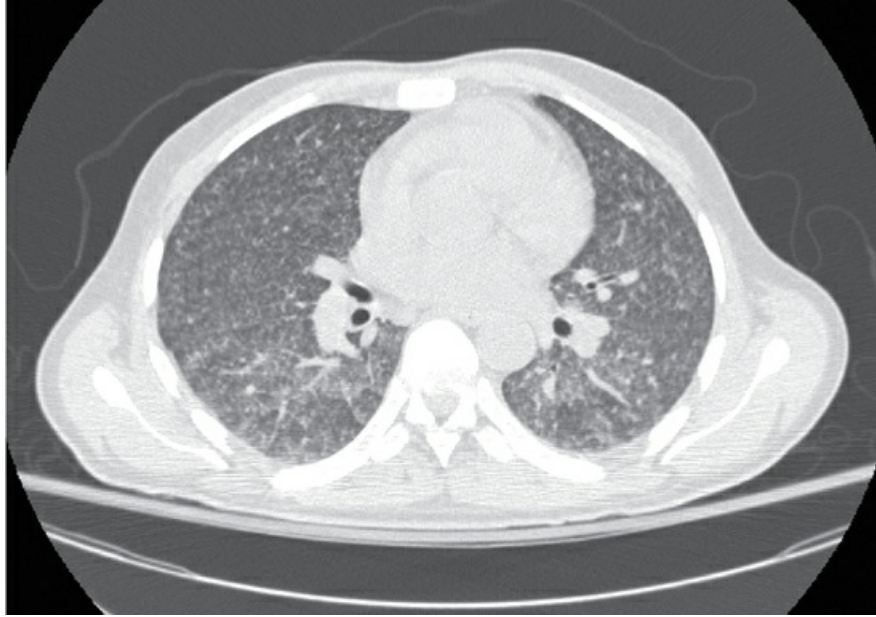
Chest CT image from a patient with miliary tuberculosis. There are countless small nodules resulting from hematogenous dissemination of *M. tuberculosis*. *Source:* (Courtesy Dr. Seth Kligerman.)
